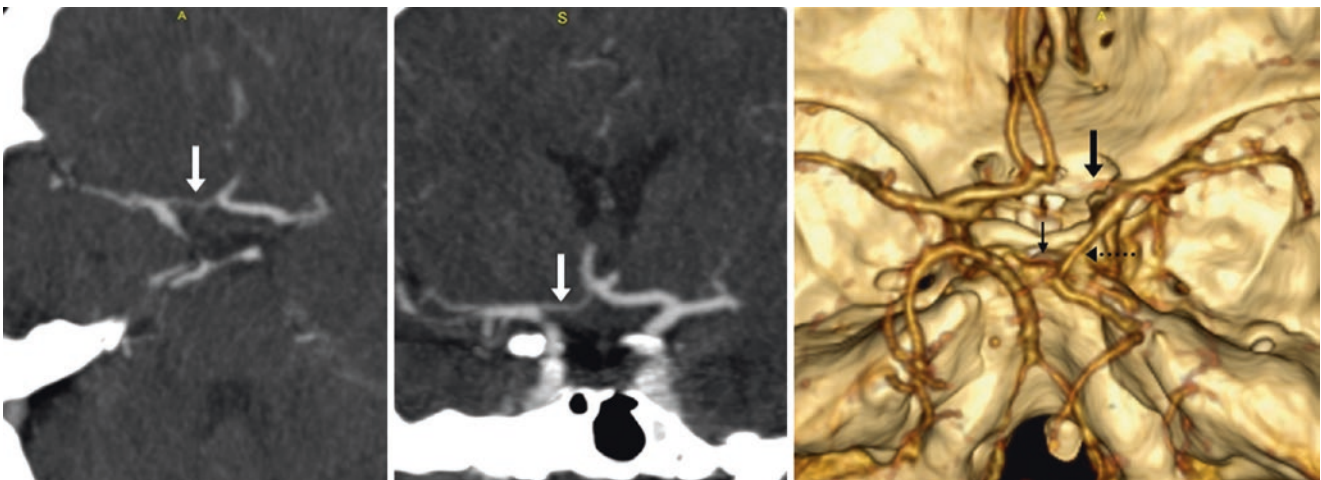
In this 60-year-old, axial (left) and coronal (middle) 5 mm-thick MPR images from a head CTA depict a hypoplastic right ACA A1 segment (arrows), confirmed on a 3D VR CTA PA view (right). Note also the severely hypoplastic right P1 segment (thin arrow), with a “fetal origin” of the right posterior cerebral artery (PCA) (dotted arrow) from the right ICA
